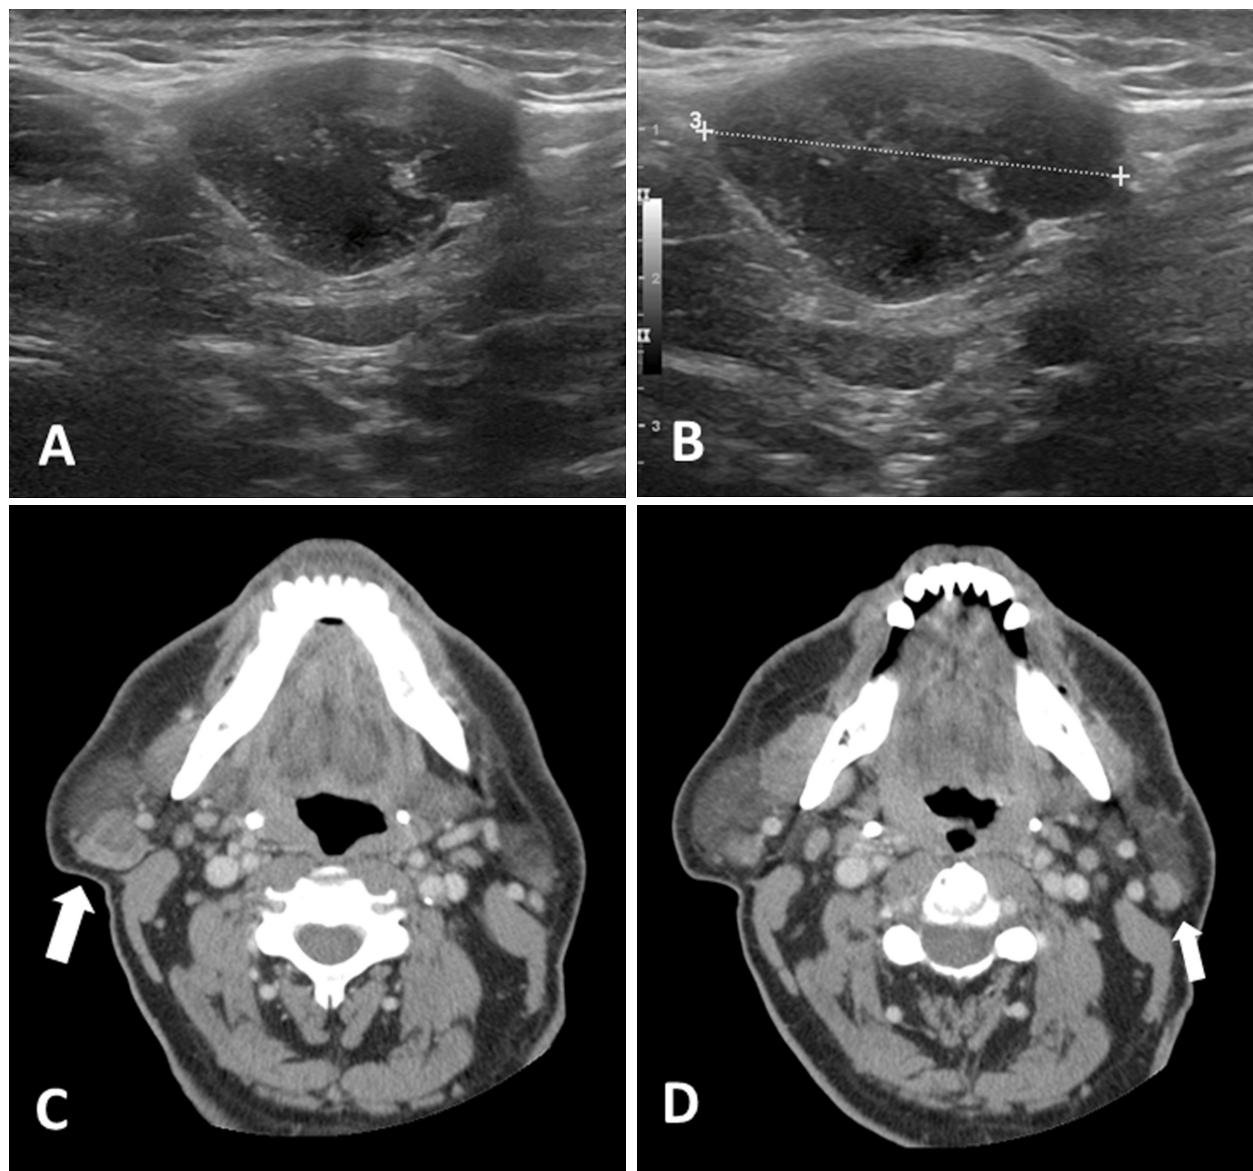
Imagistic study, ultrasonography and computed tomography (CT) scan: (A) Solid, hypoechoic lesion with well-defined borders on the right parotid gland; (B) The nodule measures 2.8 cm in its major axis; (C) Solid, sharply defined, heterogeneous nodule, contrast enhancer in the tail of the right parotid gland (arrow); (D) Hyperdense, well-delimited nodule in the tail of left parotid gland (arrow).
